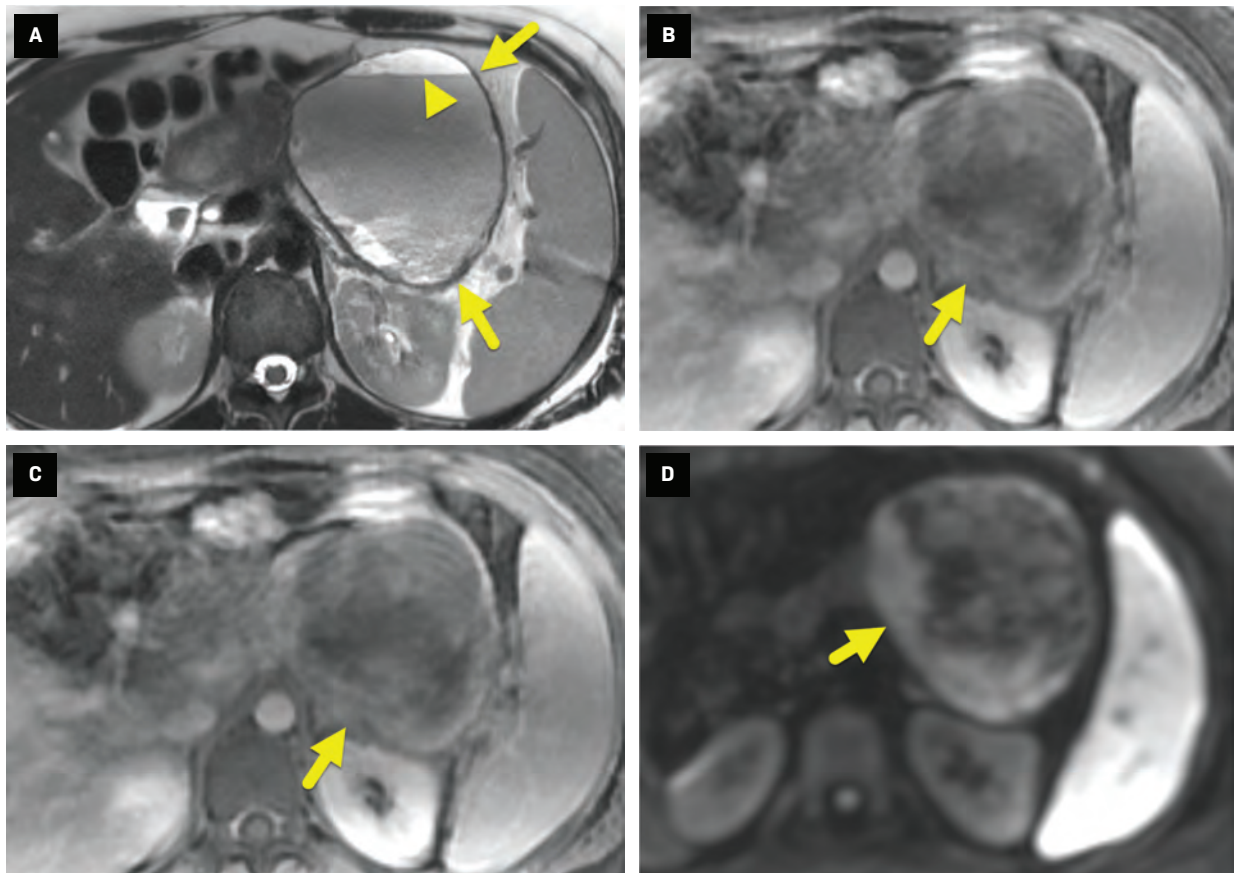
Axial T2-weighted MRI without (A) and with (B) fat suppression shows a heterogeneous pancreatic mass (arrow). The mass has layering fluid/debris within the cystic component (arrowhead in A), a heterogeneous posterior solid component, and does not contain fat. Axial T1-weighted dynamic spoiled gradient echo sequence (C) obtained 4 minutes after contrast administration shows mild enhancement (arrow) of the solid component of the mass. Diffusion-weighted sequence (b-value = 800) (D) shows restricted diffusion (arrow) in the enhancing portion of the mass.
